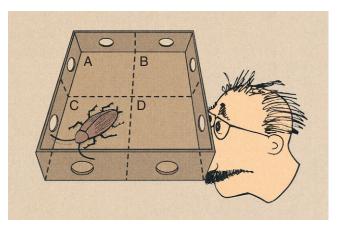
This four-pixel matrix demonstrates the method for reconstructing a computed tomography image by back projection.
